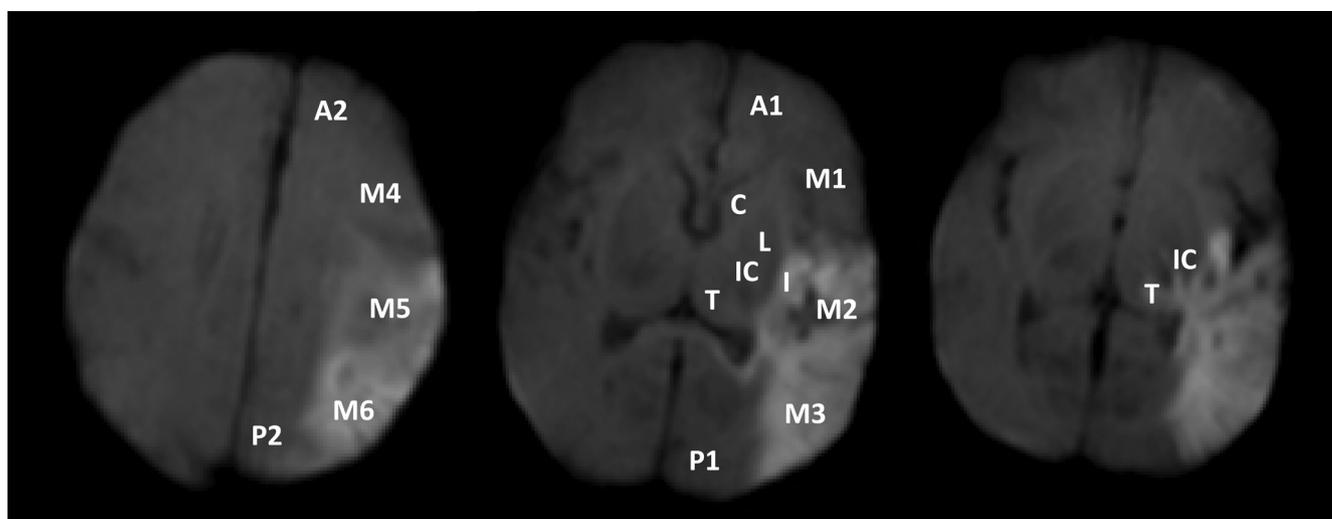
Diffusion-weighted axial MRI slices from a single patient. Labels indicate regions included in modASPECT score: anterior cerebral artery (A1–A2), MCA (M1–M6), insula (I), posterior cerebral artery (P1–P2), caudate (C), lentiform nuclei (L), internal capsule (IC), and thalamus (T). Total modASPECT score here is 7 for involvement of M2, M3, I, M5, M6, IC, and T.
